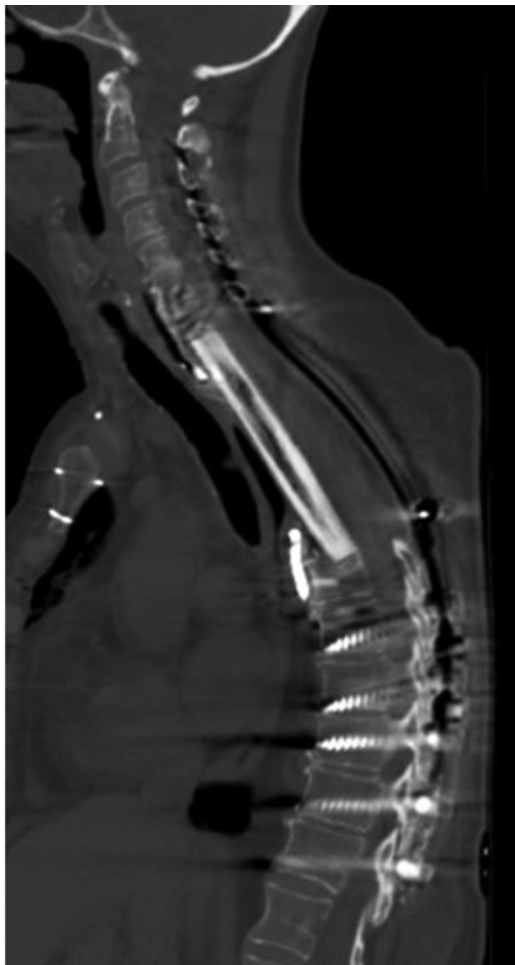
Sagittal postoperative CT image of the reconstruction with the fused FVFG 6 months after surgery.
